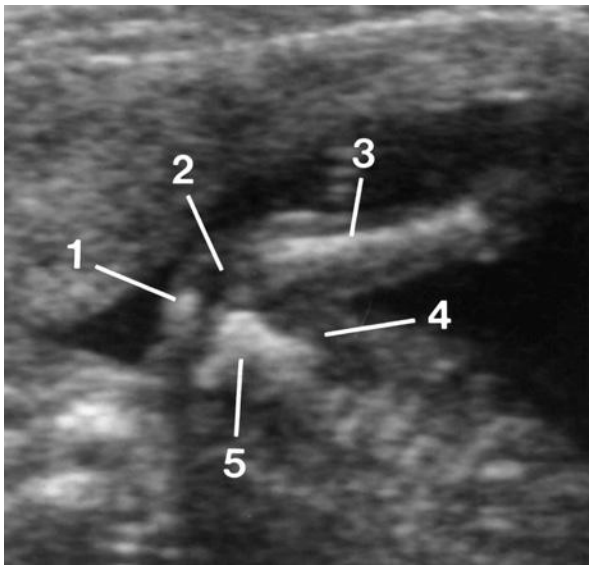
Coronal sonogram of the shoulder and upper arm. 1, distal clavicle; 2, cartilaginous humeral head; 3, ossified humeral diaphysis; 4, latissimus dorsi muscle; 5, scapula.
